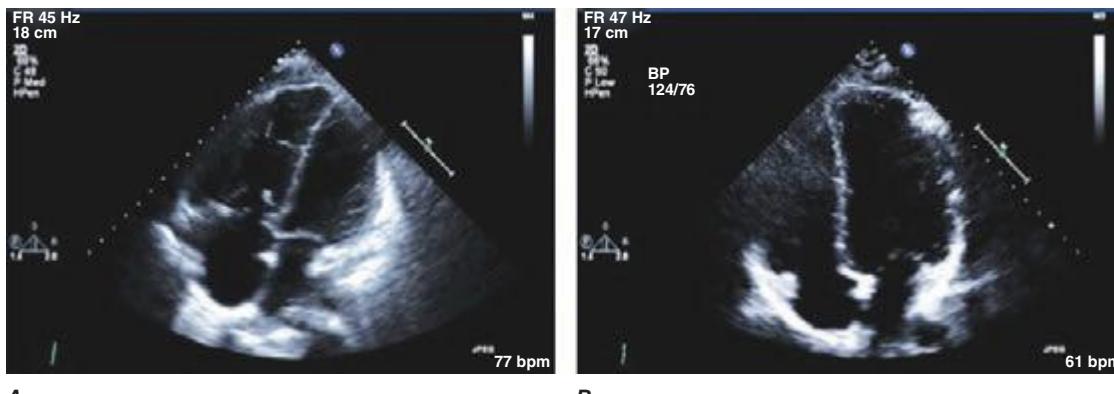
A. Representative echocardiogram showing the apical four-chamber view from a patient with pulmonary hypertension demonstrating an enlarged right atrium and ventricle with some compression of the left side of the heart. B. Same echocardiographic view showing a normal echocardiogram.
